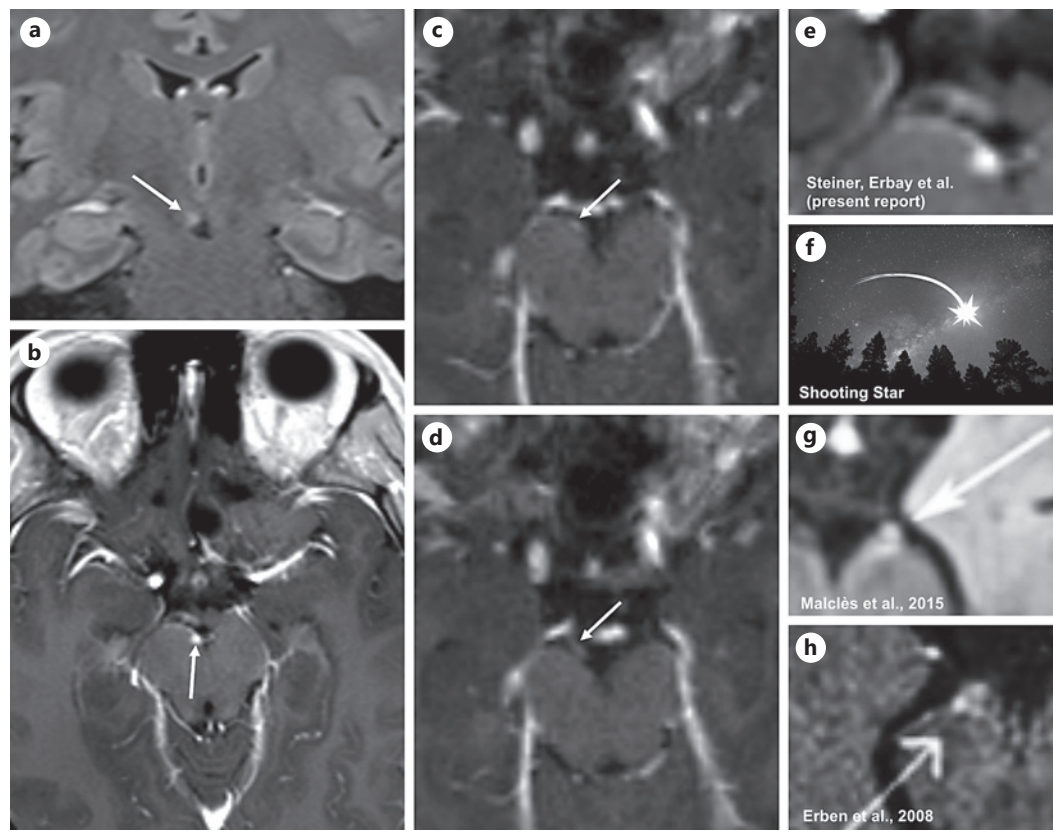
Magnetic resonance imaging of the present and previous cases of oculomotor nerve palsies in EBV-associated infectious mononucleosis. a Coronal fluid attenuated inversion recovery sequence showing a focal hyperintense edematous change at the root exit zone of the right oculomotor nerve (arrow) in the interpeduncular fossa. b Contrast-enhanced axial T1-weighted sequence reveals a mildly swollen and pathologically enhancing oculomotor nerve root exit zone (arrow). c, d On consecutive high-resolution 3D contrast-enhanced gradient echo (MPRAGE) sequences, the right oculomotor nerve is mildly thickened and abnormally enhancing along its cisternal course (arrows). e Higher magnification of (b) showing a pattern of contrast enhancement resembling a “shooting star” (f), with the focal hyperintense edematous change at the oculomotor nerve exit zone corresponding to the meteor and adjacent leptomeningeal enhancement corresponding to the visible streak of light of a shooting star. g, h Higher magnifications of MR images from previous case reports by Malclès et al. [9] and Erben et al. [10] showing a similar radiologic pattern with focal hyperintense edematous changes and leptomeningeal enhancement lining the adjacent part of the mesencephalon.
